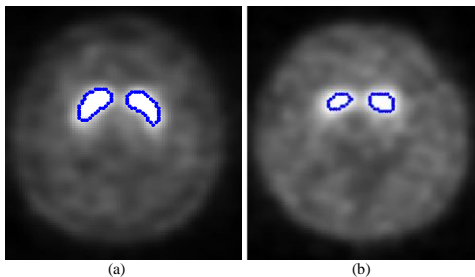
(a) Control SPECT slice and (b) Early PD SPECT slice with blue boundary of the segmented regions.
